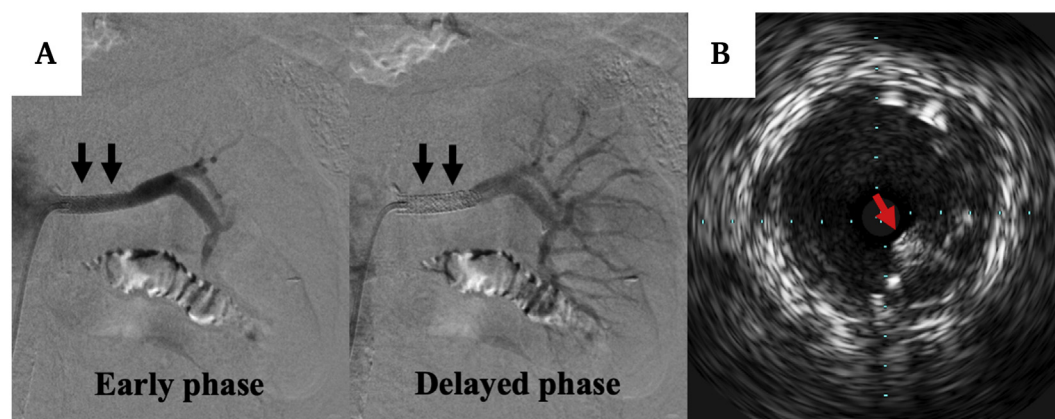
(A) Final angiogram of the left side using an adjusted digital subtraction angiography programme with diluted contrast medium showing acceptable expansion of the stents (black arrows) and favourable flow. (B) The intravascular ultrasound image at the stent distal edge shows stent deformation (red arrow).
